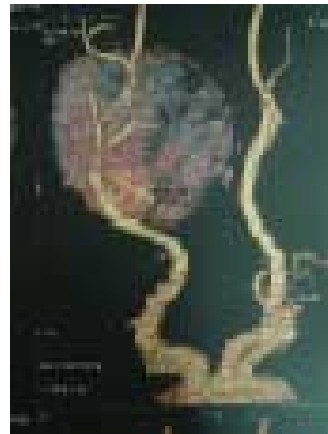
III CT Angiogram showing encasing of CCA, ICA and ECA
